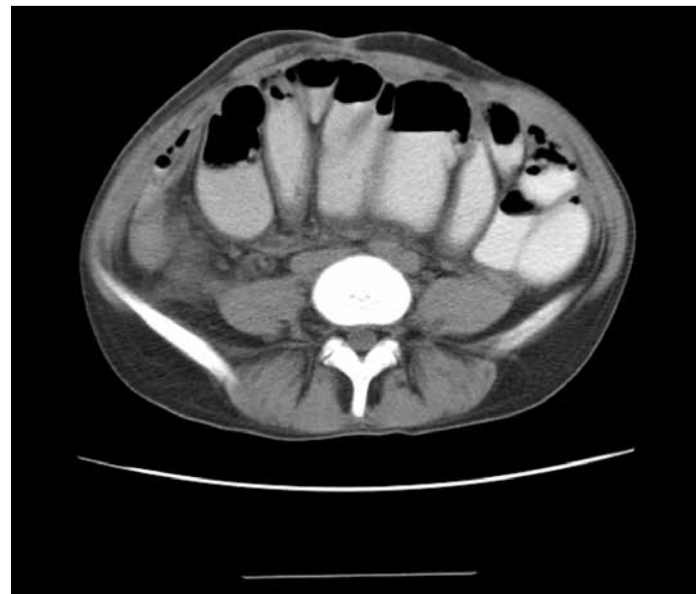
Multiple dilated ileal segments filled with oral contrast medium are shown in this enhanced axial CT of the abdomen signifying bowel obstruction.
